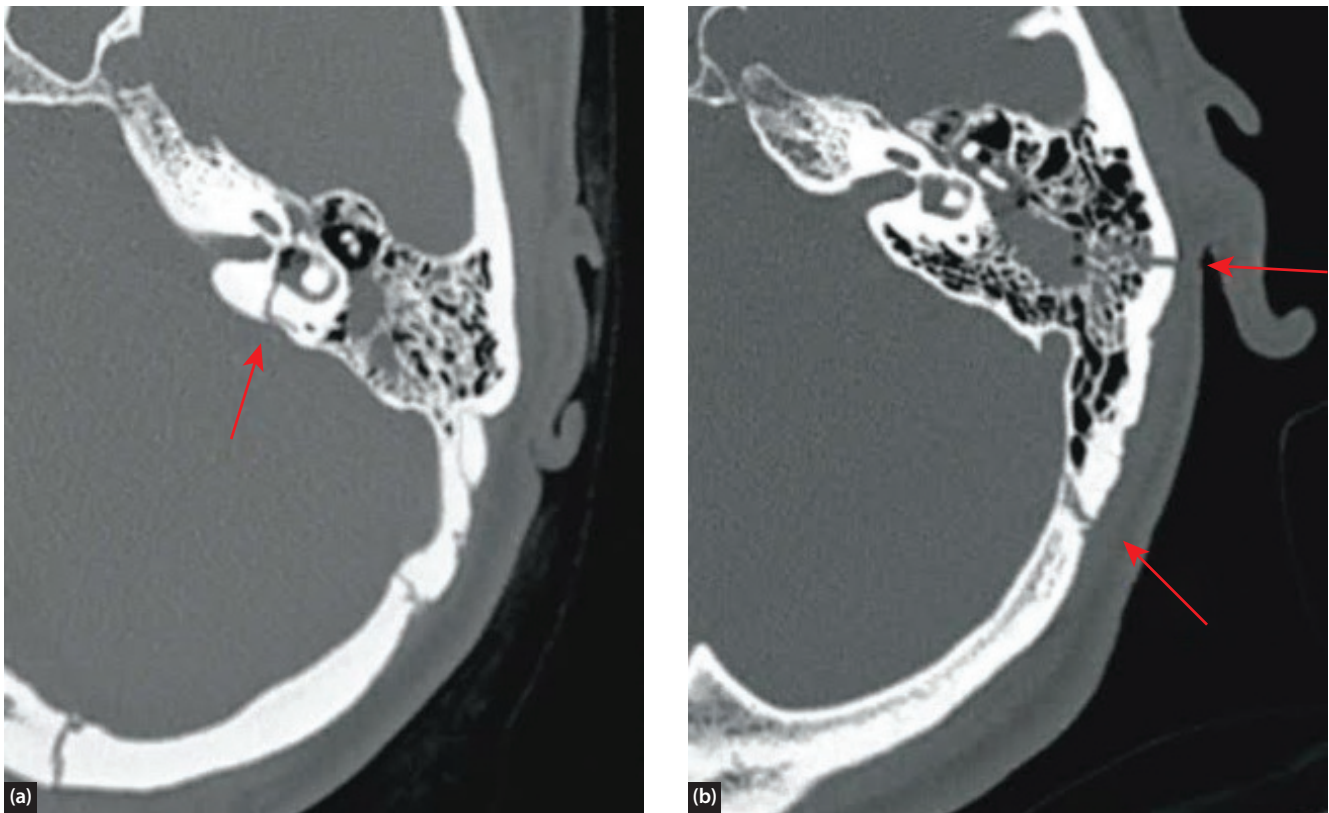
High-definition CT scans demonstrating (a) otic capsule-sparing and (b) otic capsule-violating fractures.
